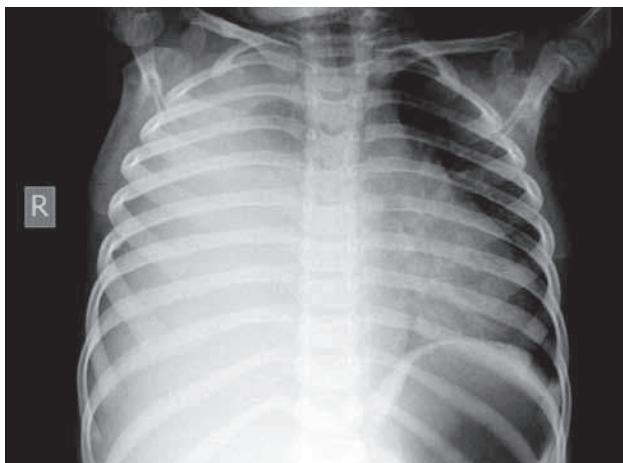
Chest X-ray: Opacification of right lung with contralateral mediastinal shift.
